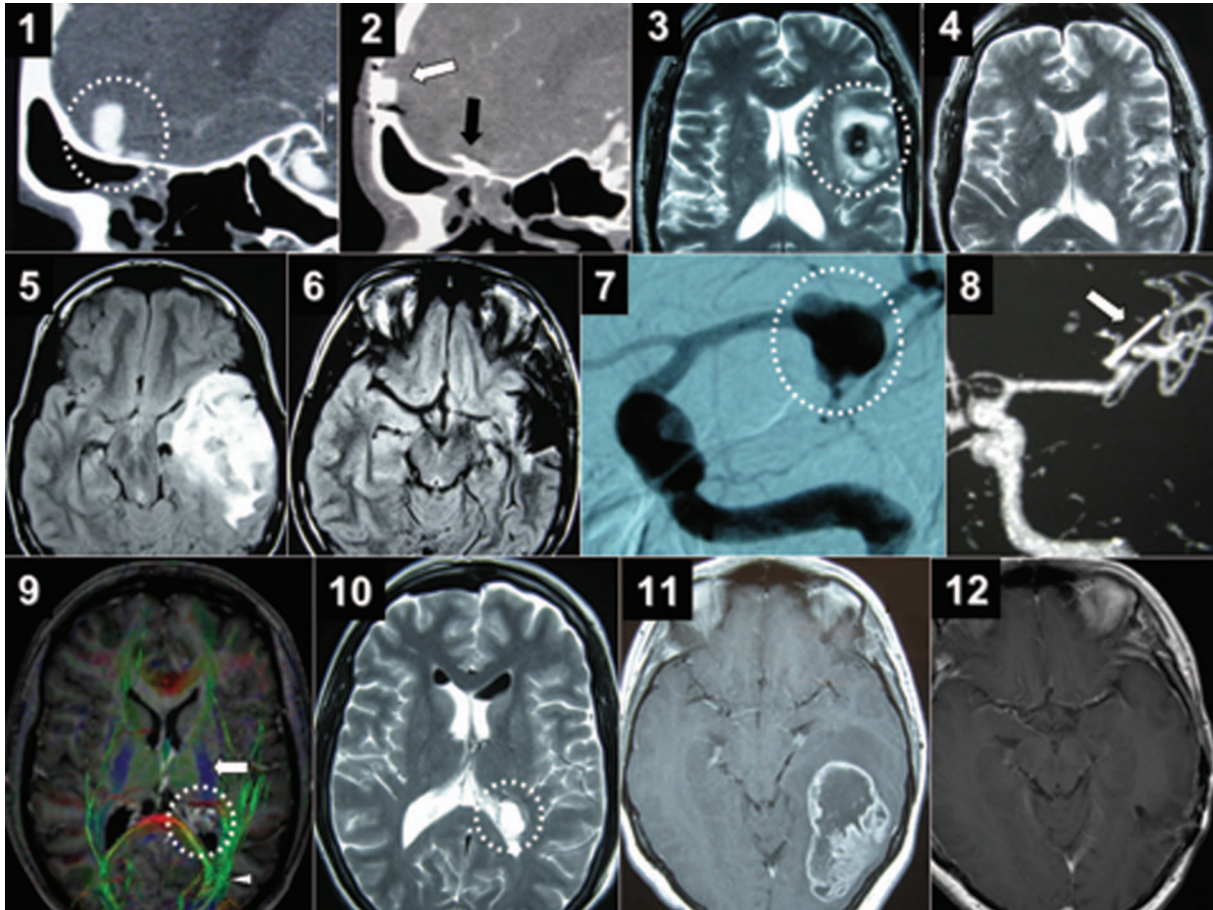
Collage of paired pre- and post-operative images representing a variety of pathologies surgically treated with patients awake in this series (Patients 1, 4, 12, 14, 15 and 16, respectively, in Table I). Patient 1 – awake for vision: Orbitofrontal dural arteriovenous fistula threatening vision pre-operatively. Pre-operative sagittal CT angiogram (1) shows fistula vessels and venous aneurysm in circle. Post-operative CT angiogram (2) shows frontal mini-craniotomy (white arrow) and surgical clips (black arrow). Patient 4 – awake for language: Broca area cavernoma presenting with progressive dysphasia. Pre-operative (3) and post-operative (4) axial T2 MRI. Patient 12 – awake for language and movement: insula anaplastic oligodendroglioma with recent impending herniation. Pre-operative (5) and post-operative (6) axial FLAIR MRI. Patient 14 – awake for language and movement: Fusiform middle cerebral artery aneurysm presenting with thromboembolic events. Pre-operative (7) catheter angiogram and post-operative (8) CT angiogram (white arrow shows aneurysm clips). Patient 15 – awake for vision and movement: Left atrial cavernoma presenting with headache. Pre-operative (9) contrast axial T1 MRI with tractography. Lesion shown in circle. Tract lateral and posterior to lesion = optic radiation (arrow head). Tract anterior to lesion = posterior limb of internal capsule (arrow). Post-operative (10) axial T2 MRI following excision. Patient 16 – awake for language and vision: Left temporal-occipital lobe glioblastoma multiforme presenting with dysphasia. Pre-operative (11) and post-operative (12) contrast axial T1 MRI. The patient is currently free of macroscopic tumour at 27 months post-op.
